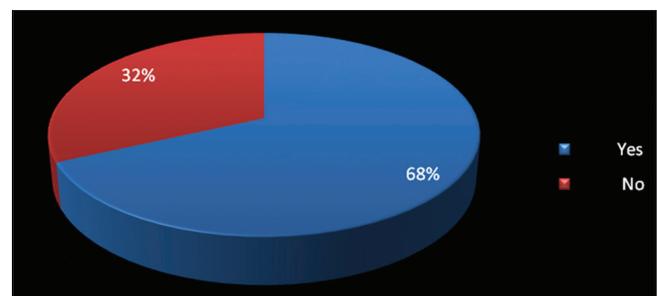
Frequency distribution of subjects when asked whether they have heard of cone beam computed tomography used specifically for dentistry
